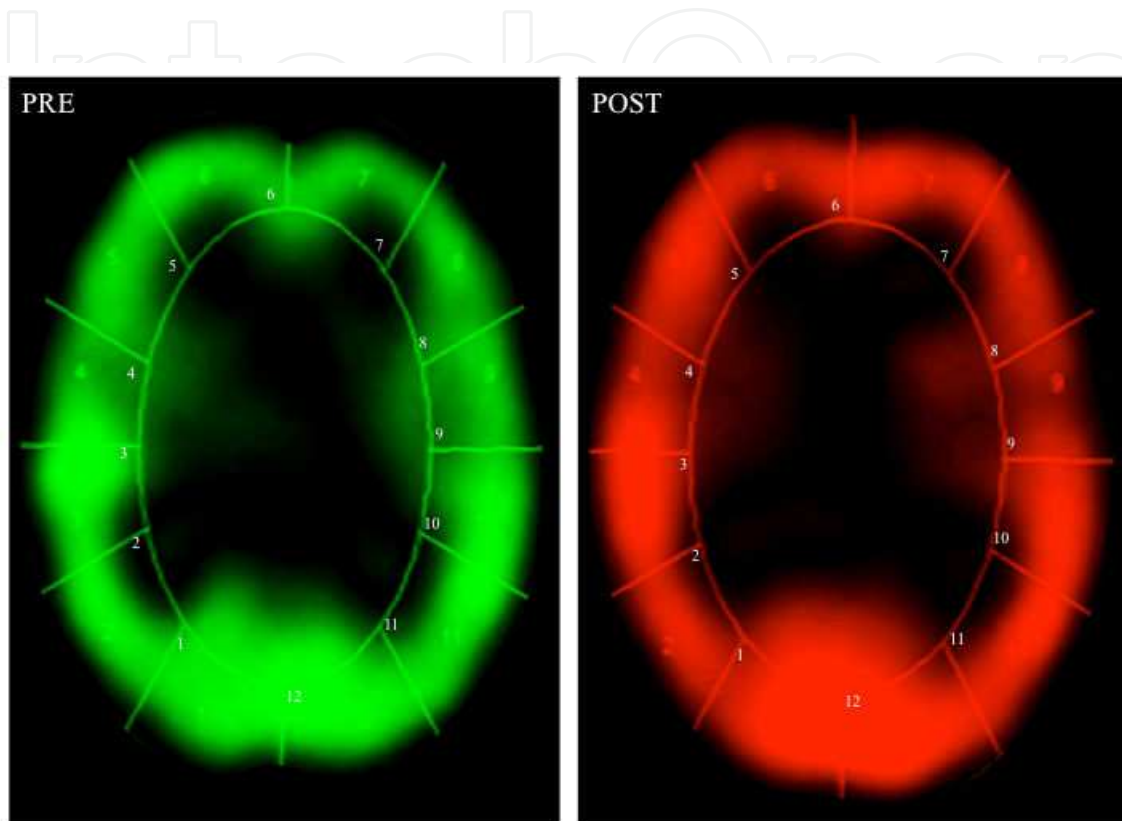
Pictures of the brain SPECT of a girl of 6 years of age. Green shows the status prior to treatment, color red shows the status 4 months after treatment with botulinum toxin. The right hemisphere (left side of the pictures) include zones 1 to 6, from bottom to up and the left hemisphere (right side of the picture) comprises de zones 7 to 12 from bottom to up.
